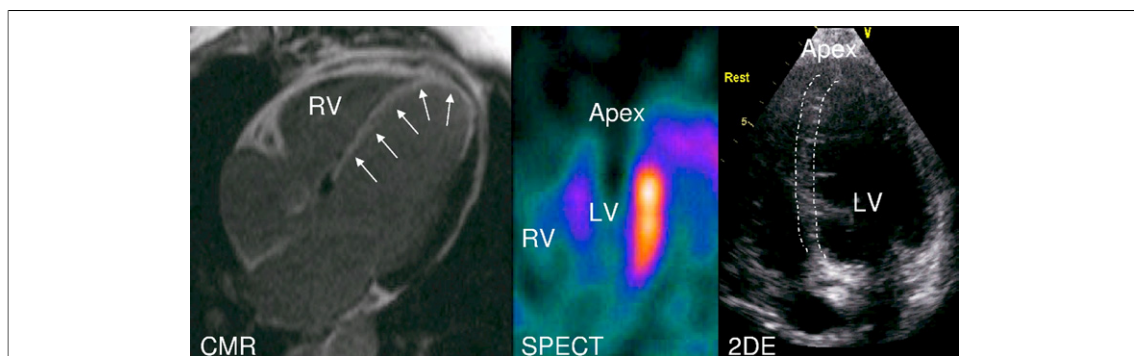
CMR, SPECT, and 2DE in a Middle-Aged Man After Acute Anteroseptal Myocardial Infarction
